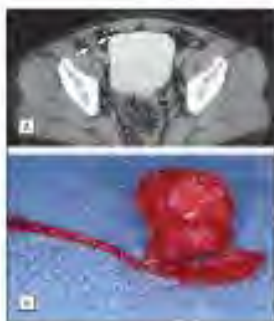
A meshoma with long process and encasement of the iliohypogastric nerve (A) and a computed tomographic image of the meshoma (B). The iliohypogastric nerve (arrow) is completely encased within the fold of a mesh plug.
